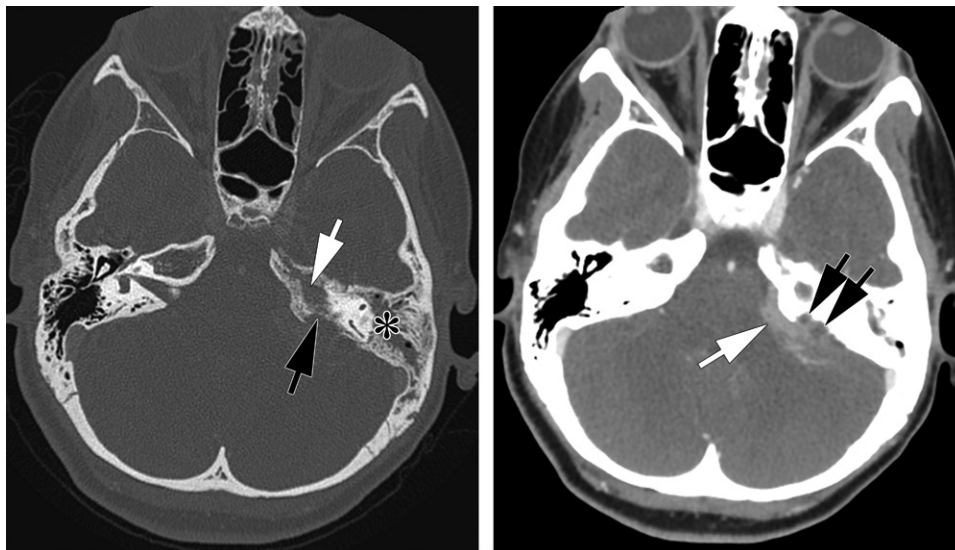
Left petrous apicitis in an 11-year-old girl who presented with ear drainage and diplopia. (a) Axial contrast-enhanced CT image (bone window) shows left tympanomastoid opacification (*), as well as opacification and coalescence of air cells at the petrous apex (white arrow). There is also bone dehiscence (black arrow) along the dorsal aspect of the petrous apex. (b) Image in a obtained in soft-tissue windows shows epidural phlegmon (white arrow) and nonenhanced foci (black arrows), consistent with abscess.
